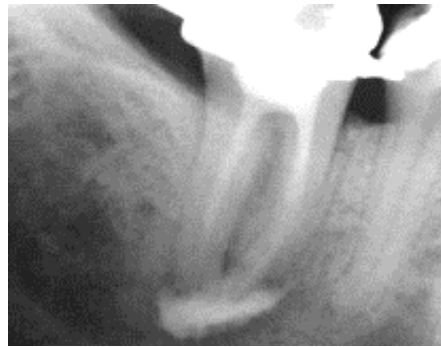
Radiopaque dye extended into periapical tissues in teeth with necrotic pulps
